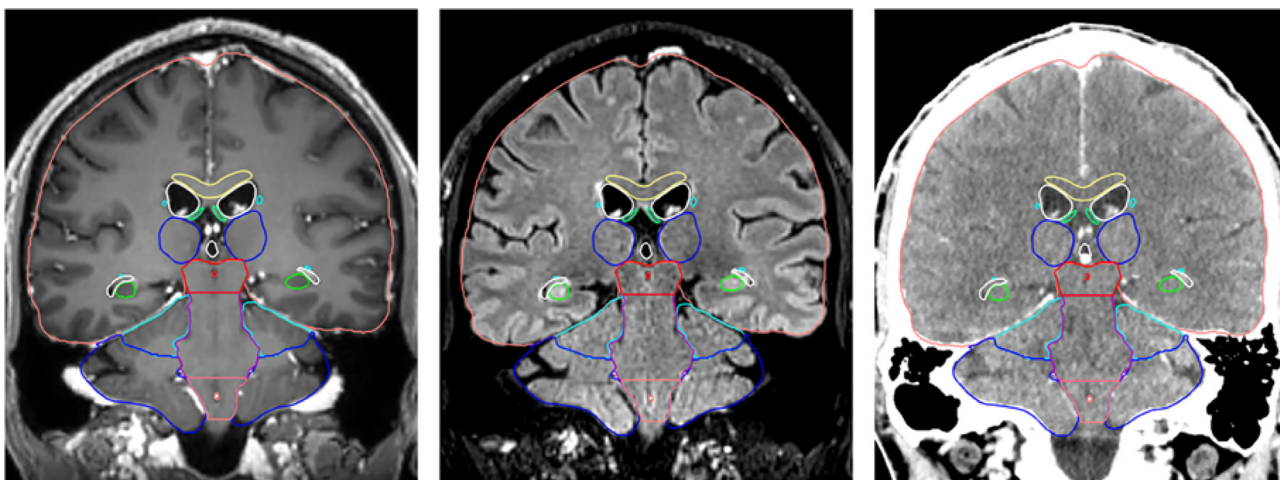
Visualisation of the organs at risk in the coronal plane, from left to right: 3 T MRI T1Gd, 3 T MRI T2 FLAIR, and CT (brain window). Colour legend (in alphabetical order): Brainstem [Midbrain: red, Pons: purple, Medulla oblongata: pink]; Caudate nucleus: cyan; Cerebellum [anterior: cyan, posterior: blue]; Corpus Callosum: pale yellow; Fornix: green; Hippocampus: green; Supratentorial brain: salmon; Thalamus: blue; Ventricles: white.
